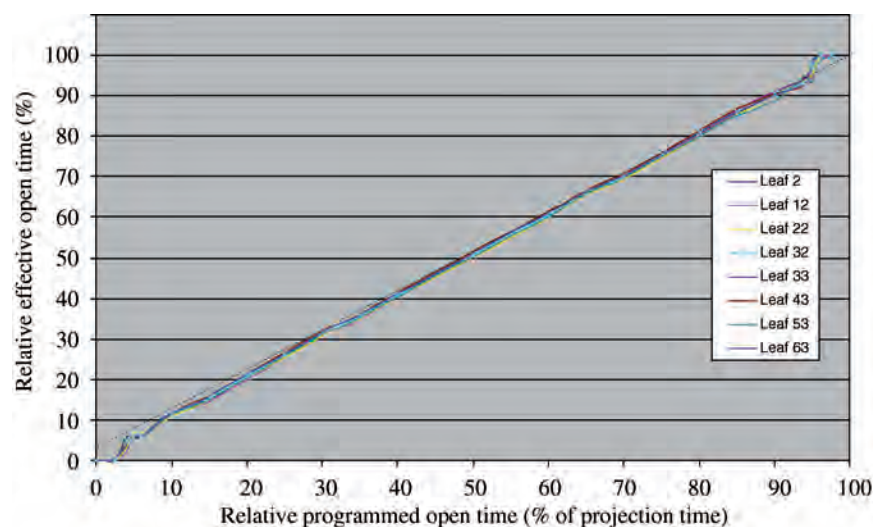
Binary collimator leaf-performance information used for monitor-unit calculations on the Hi-Art™ helical tomotherapy unit. This figure shows the effective open time as a percentage of the time for one projection, here 500 ms long, for binary leaves when compared with their programmed open-time request. In helical tomotherapy, a single rotation is divided into 51 arc segments called projections; a projection lasts a time equal to the time for one complete rotation divided by 51. The programmed relative open time (%) is varied from very small values to the full projection time of 500 ms, and the time that the leaf is actually open is determined by processing of the megavoltage x-ray detector signal. The x-ray detector acquires a reading for every channel for every linac pulse, allowing a temporal resolution of about 3 ms or about 0.6 % of the projection time to determine when the leaves are opened or closed. The control of the leaves is such that all of the leaves at the beginning of a projection are closed. The finite leaf opening and closing time prevents a leaf from achieving a relative opening time greater than about 95 %. To deliver a very small opening time, a leaf has to begin to open and, then before it is fully open, it must start to close. It can be seen that relative opening times less than about 5 % are not possible. The dynamic range of modulation for a binary collimator controlled in this manner is continuous but with a range smaller than the projection time. The curves, one for each leaf listed, are nearly superimposed indicating similar opening and closing times. A dashed line indicates a line defining equal requested and effective open times. This measured performance of individual leaves is used in the monitor-unit calculation to determine what the leaf opening times should be. (Figure courtesy of TomoTherapy Inc., Madison, WI, USA; reproduced with permission.)
